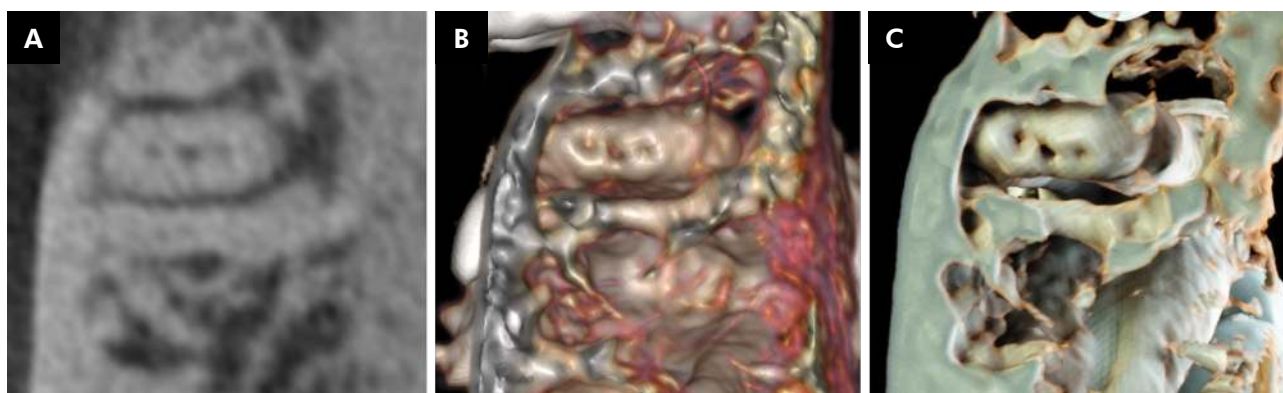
Case 4 (A-C). CBCT scans showed a tooth #46 with root canal retreatment, secondary infection and widening of the periodontal space. The patient complained of sensitivity in this region. In the CBCT scan navigation it was possible to identify 3 apical foramina in the mesial root. The photorealistic 3D rendering tool (C) provided a better view that the conventional volumetric rendering and confirmed the presence of a middle-mesial foramen with a larger dimension, that appeared in the apical third of the mesial root.
